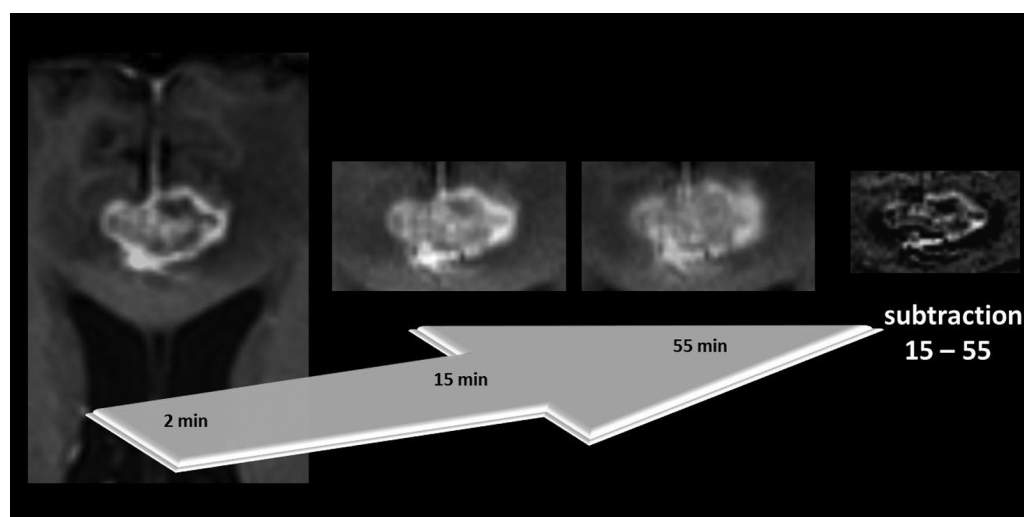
Tumor recurrence in a 68-year-old man with a metastasis from renal cancer treated with SRS. From left to right, axial T1-weighted MR images 2min, 15min, and 55min after contrast agent administration with subtraction image 15min minus 55min. The subtraction image shows—in contrast to the radiation-induced injury in Fig. 1—white components in the inner area of the lesion. The border of the lesion is still sharp 15min after injecting contrast. Although the lesion loses signal intensity from 15min to 55min, the signal intensity contrast between the rim and the inner area remains for up to 55min.
